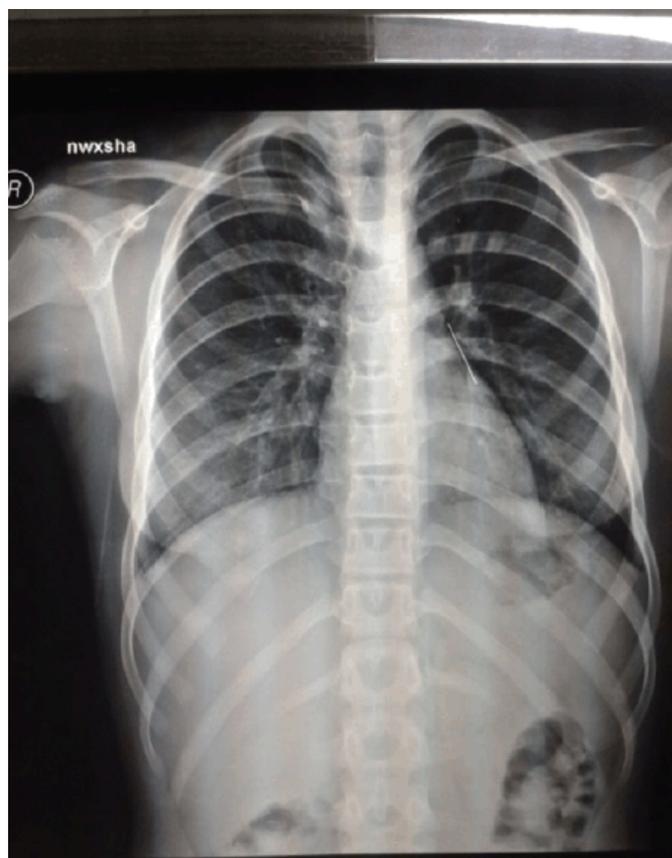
Posteroanterior view of chest radiograph showing scarf pin in the left middle zone. Taken with permission from Baram et al. [2].
